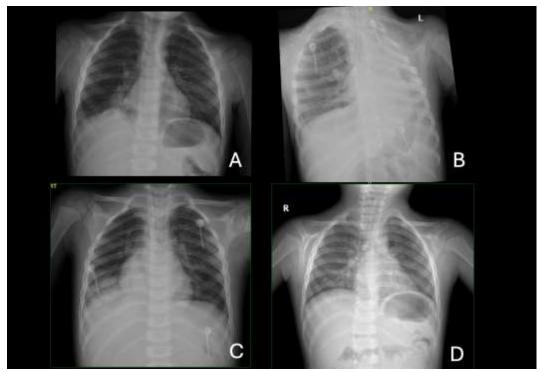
(A) Chest X-ray on arrival to ED, (B) Chest X-ray on day 2, (C) Chest X-ray on day 4, (D) Chest X-ray on 2 weeks after discharge.
